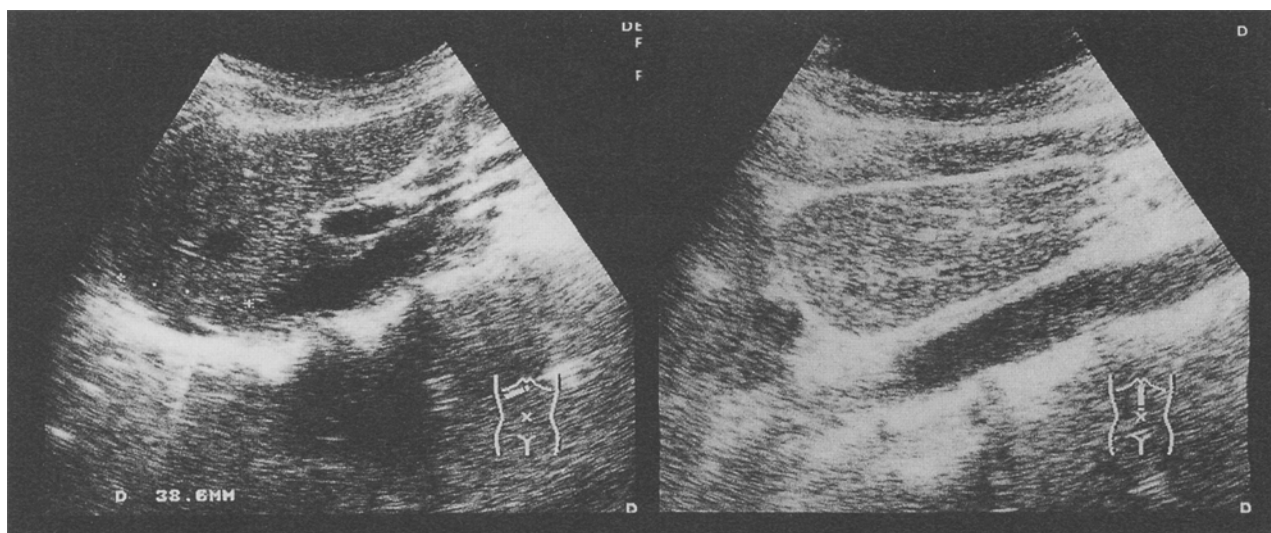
Ultrasonography of the liver of the patient described in Fig. 1, taken before chemotherapy. A space-occupying lesion is found in the S2 region of the liver (left). After chemotherapy, the lesion has completely disappeared (right).
